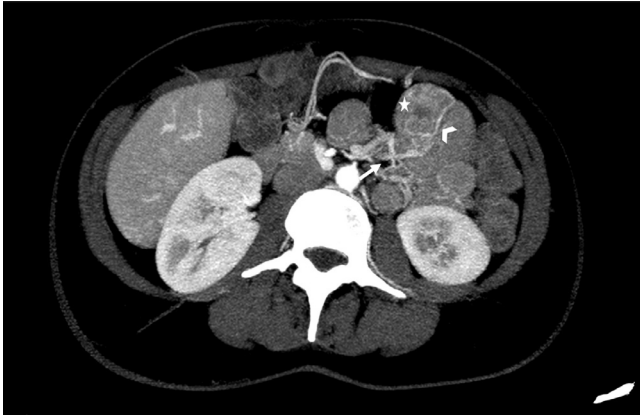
Jejunal wall lesion with tumor induced neoplastic angiodysplasia. Axial contrast-enhanced CT image, arterial-phase, MIP reconstruction, shows congestion and inhomogeneous mural enhancement of jejunal wall (star), with coexistence of intramural swollen vessels (arrowhead) and associate early impregnation of mesenteric drainage veins (harrow).
